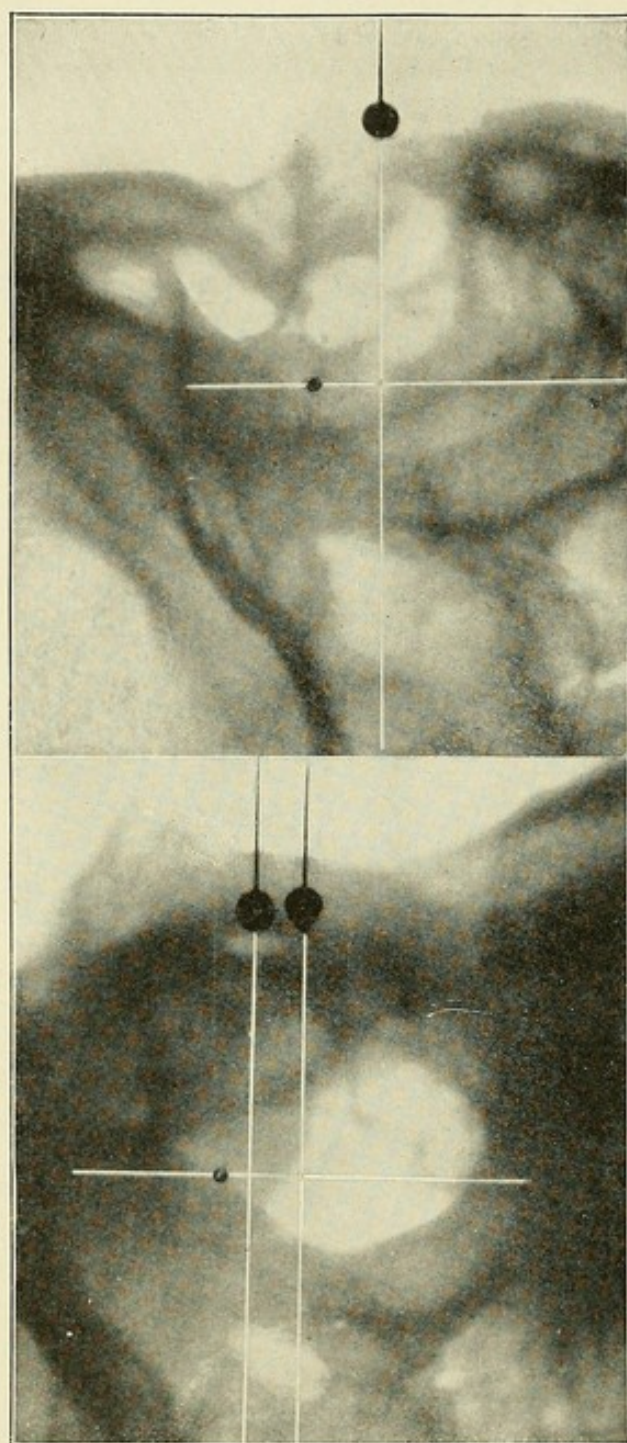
X-ray in eye surgery. Oblique position.
